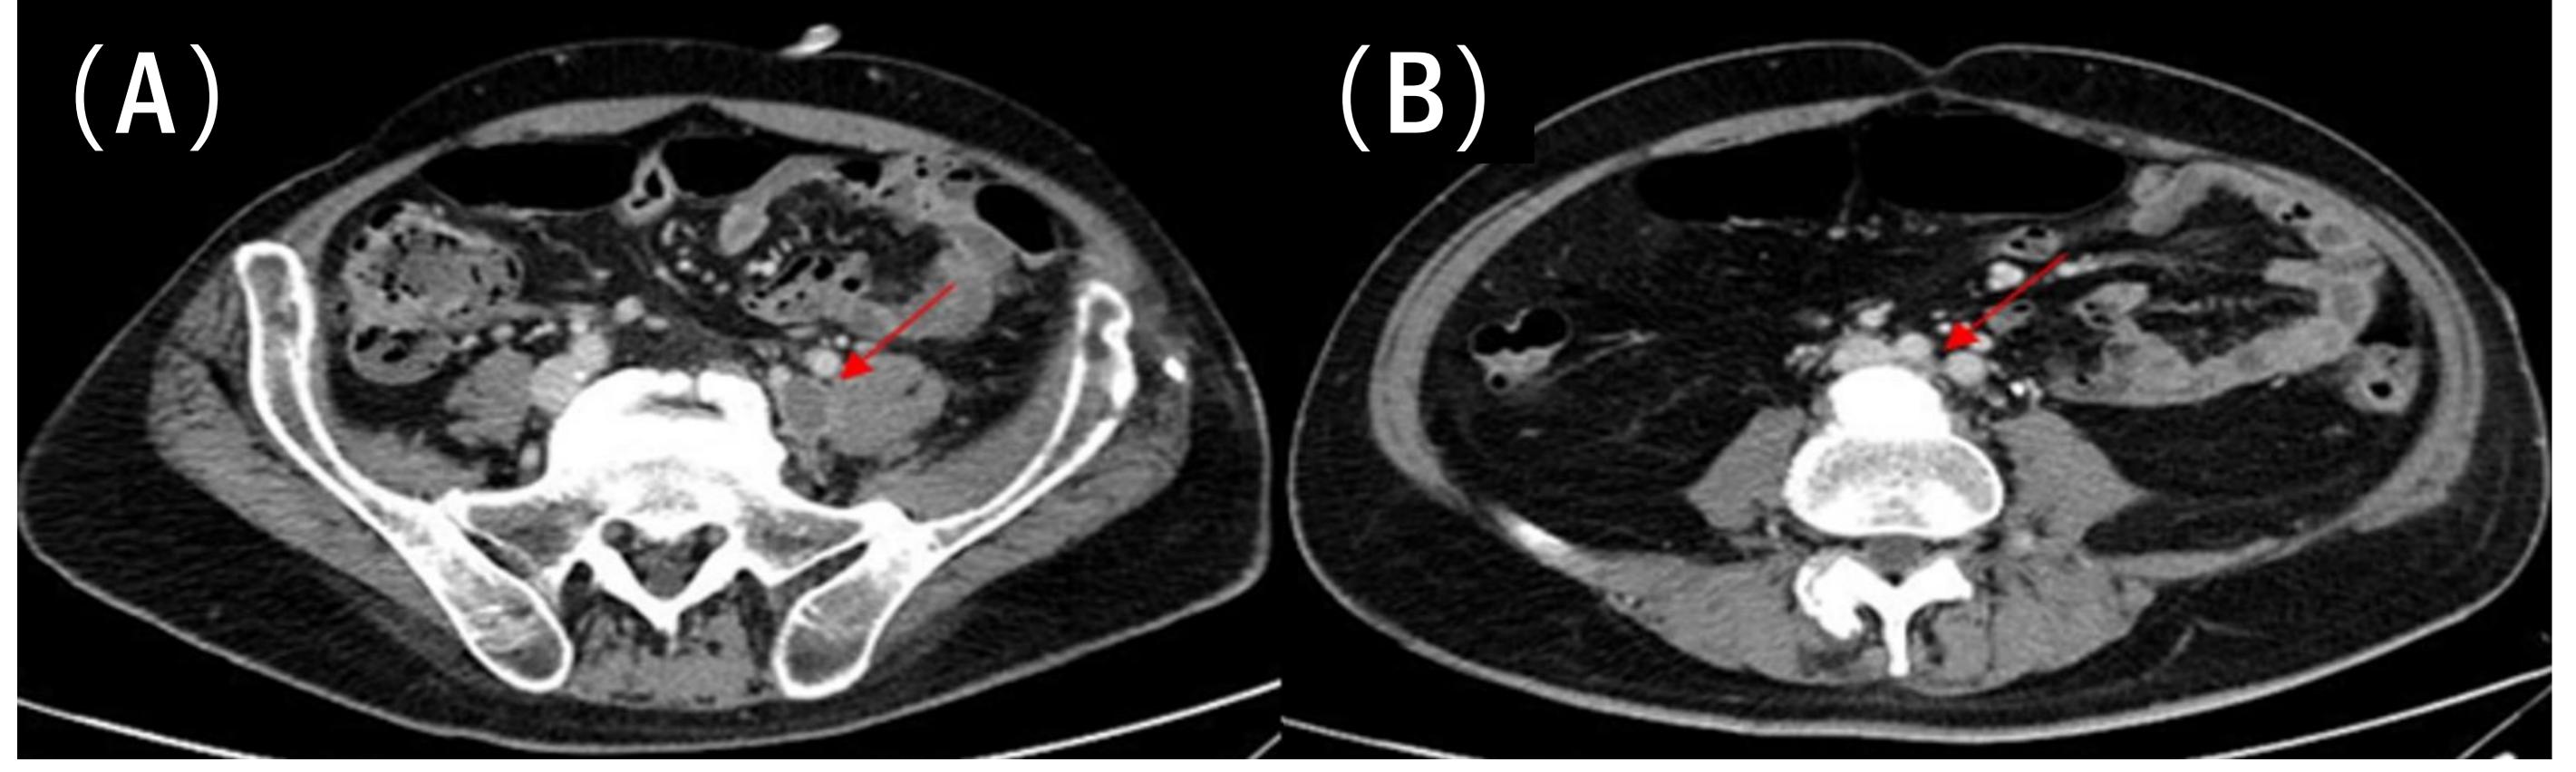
CT abdomen and lower extremity venography findings. (A) In axial view, multifocal filling defects due to thrombus throughout the left ilio-femoral vein are noted (arrow). (B) In axial view, the left common iliac vein compression due to the right common iliac artery and NHO of lumbar spine is noted (arrow).
